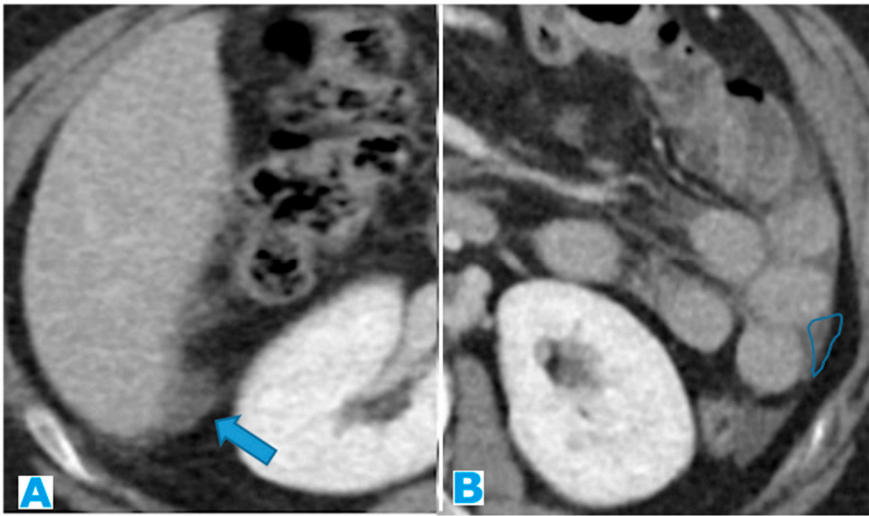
Axial CE-CT (A, B). PC from ovarian carcinoma: Minimal ascites within the subhepatic space (arrow on A) and between the SB loops, triangle shaped (B).
